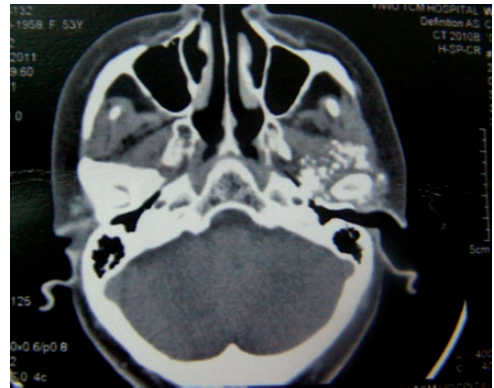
Preoperative axial computed tomography scan of the temporomandibular joint region. The image shows radiodense bodies surrounding the left condyle.
